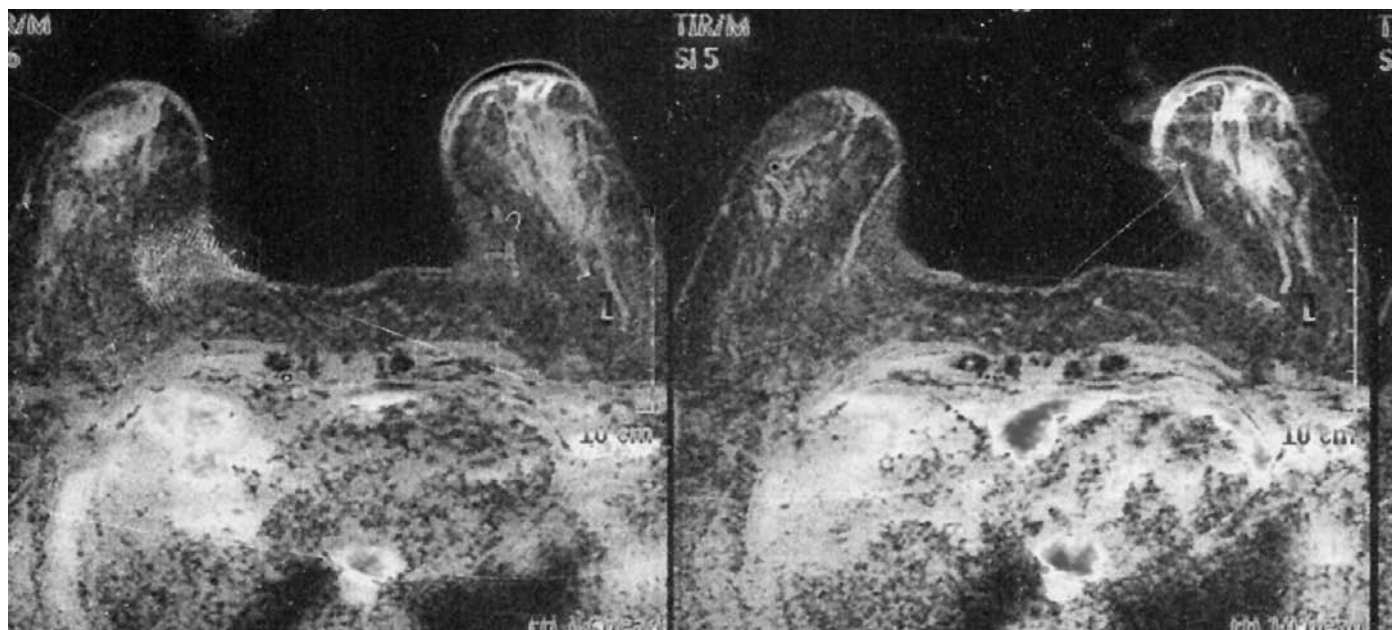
MRI of left breast (before surgery) shows a hyperintensity, evident in STIR sequences, on skin planes and ductal course
